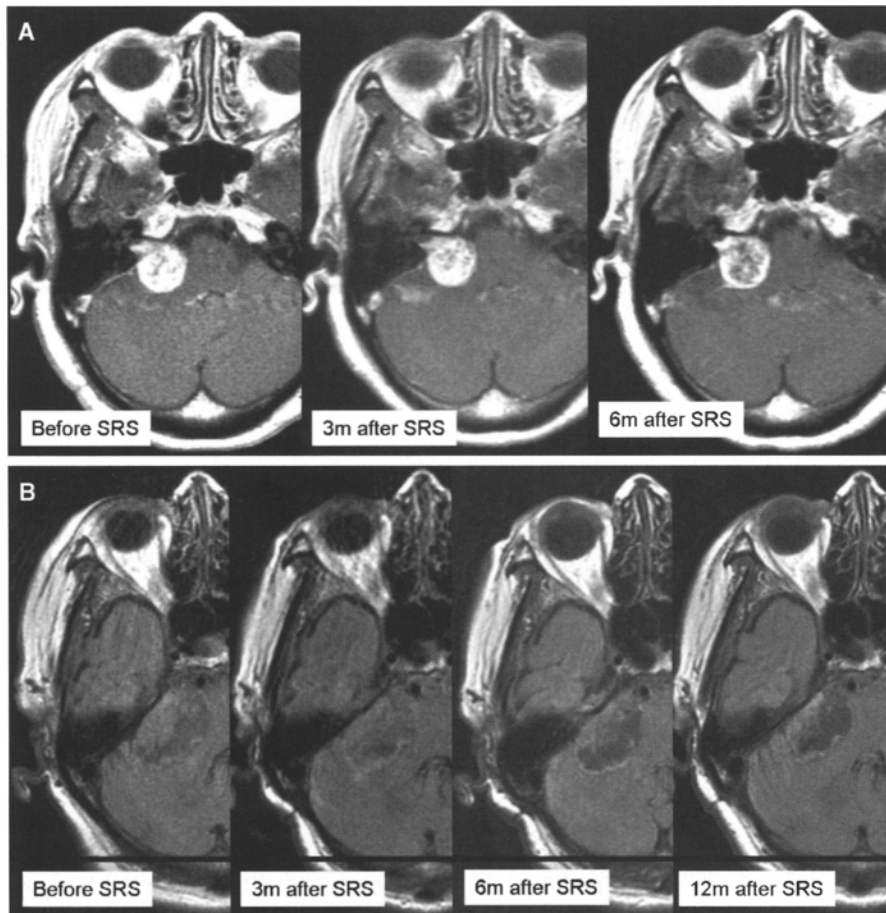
(A) Series Gd-enhanced T1W MRI: gradually loss of central enhancement 6 months after CK SRS. (B) Series T2W flair image for 12 months follow up: no evidence of new perifocal edema around brain stem or cerebellum even though tumor diameter was around 4.2 cm in diameter
